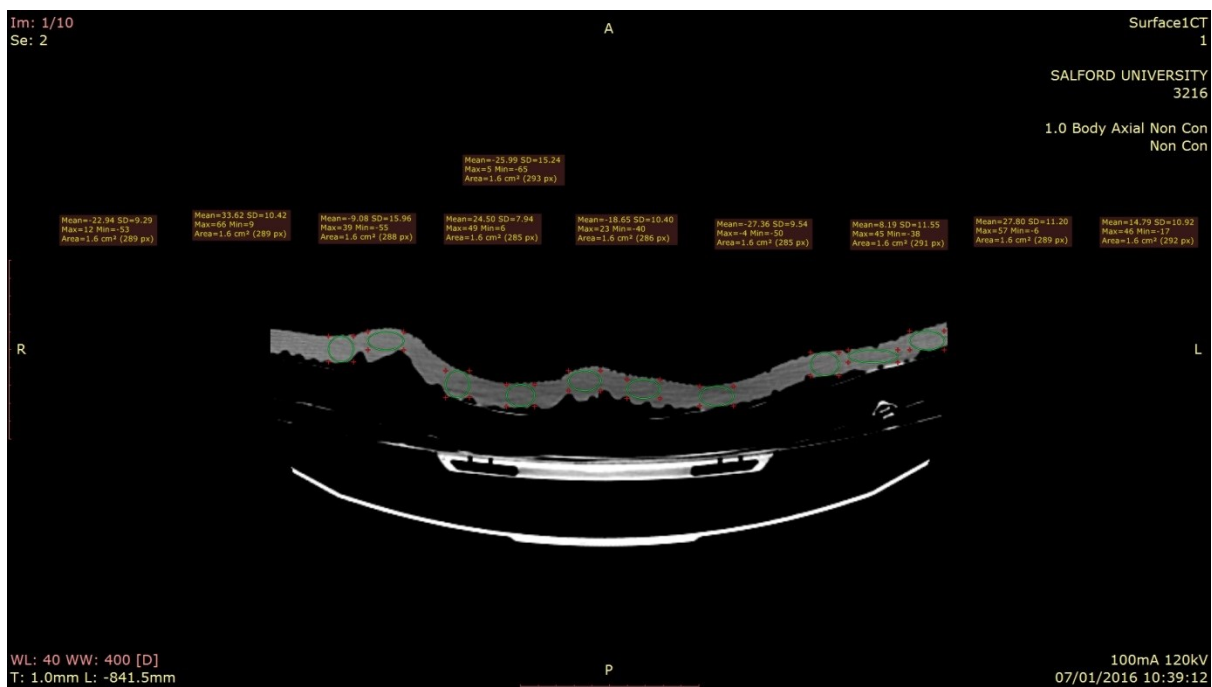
4: A CT image of the thick gel surface overlay showing massive heterogeneity in its internal structures
